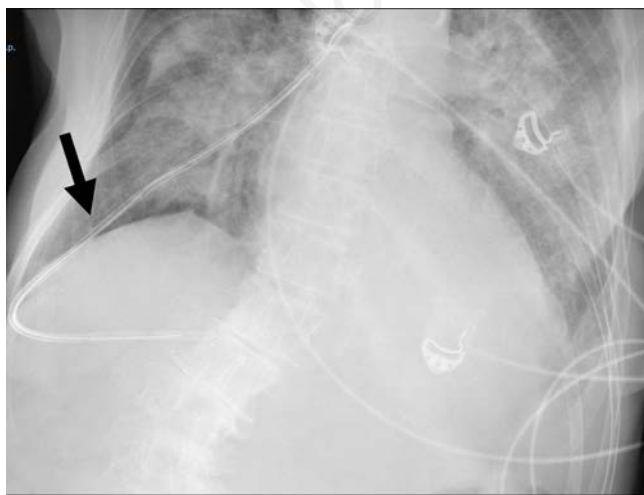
Naso-enteric tube with its distal end projecting at the right basal site seen by X-rays.
